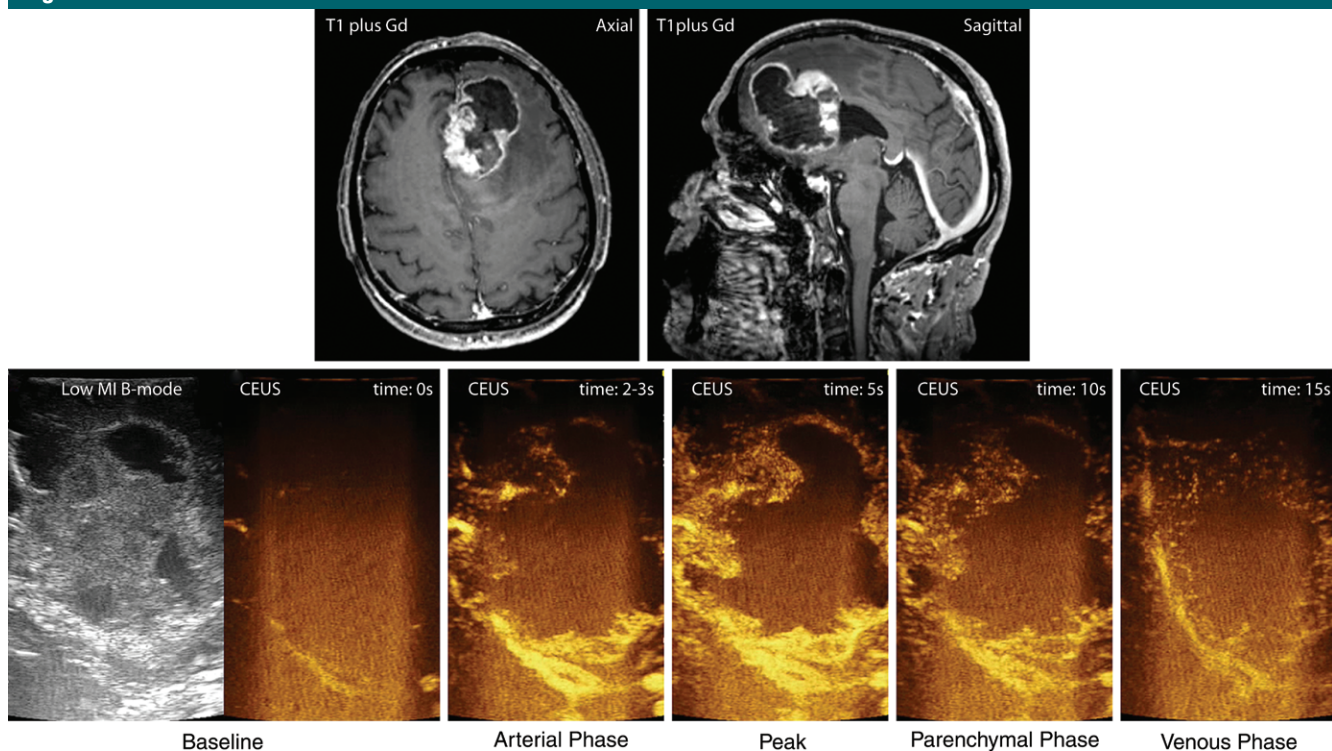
Contrast enhancement phases. Images of left frontal GBM in 49-year-old woman. Top row, preoperative T1-weighted gadolinium-enhanced MR images in axial and sagittal planes. Bottom row, contrast-enhanced US (CEUS) scans show enhancement phases. In arterial phase, main feeding arteries are visible. In peak and parenchymal phases, it is possible to distinguish more solid and cystic and/or necrotic areas. In venous phase, movement of microbubbles makes small draining veins recognizable. *Gd* = gadolinium, *MI* = mechanical index.
